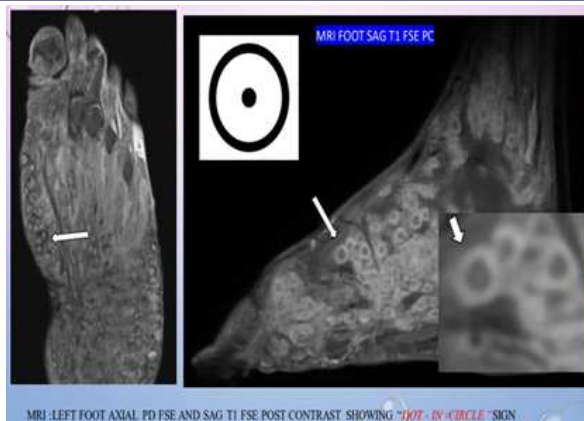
MRI of the left foot demonstrates multiple rounded lesions showing the "dot-in-circle" sign on axial proton density FSE and sagittal post-contrast T1 FSE images. The lesions appear as hyperintense nodules with central hypointense dots (white arrows), corresponding to grains within granulomas.
